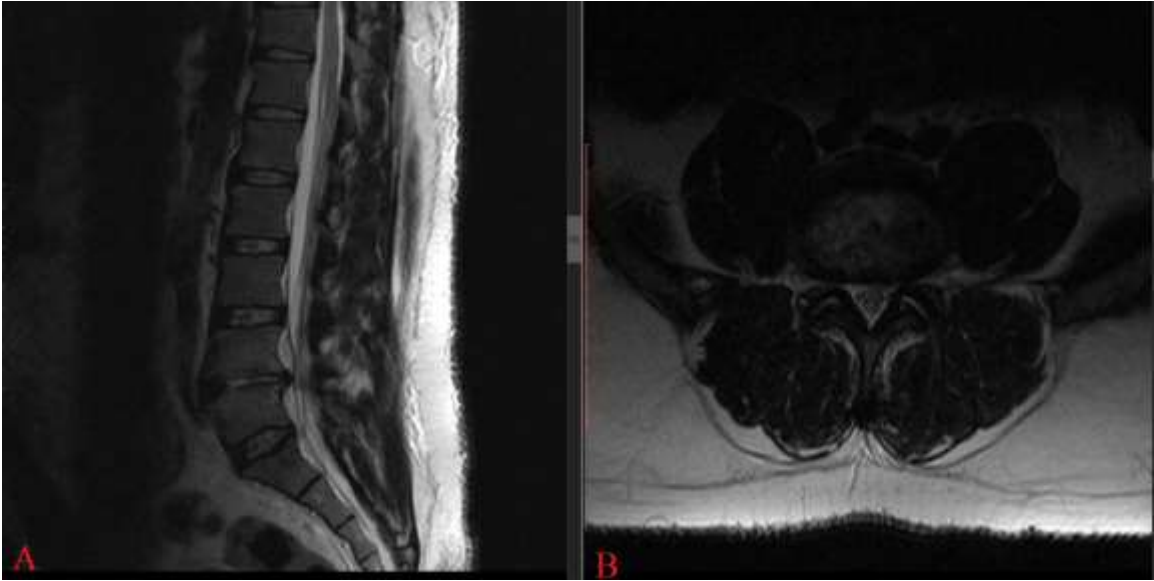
/B: Sagittal & Axial MRI demonstrating herniated disc at L4-L5.
